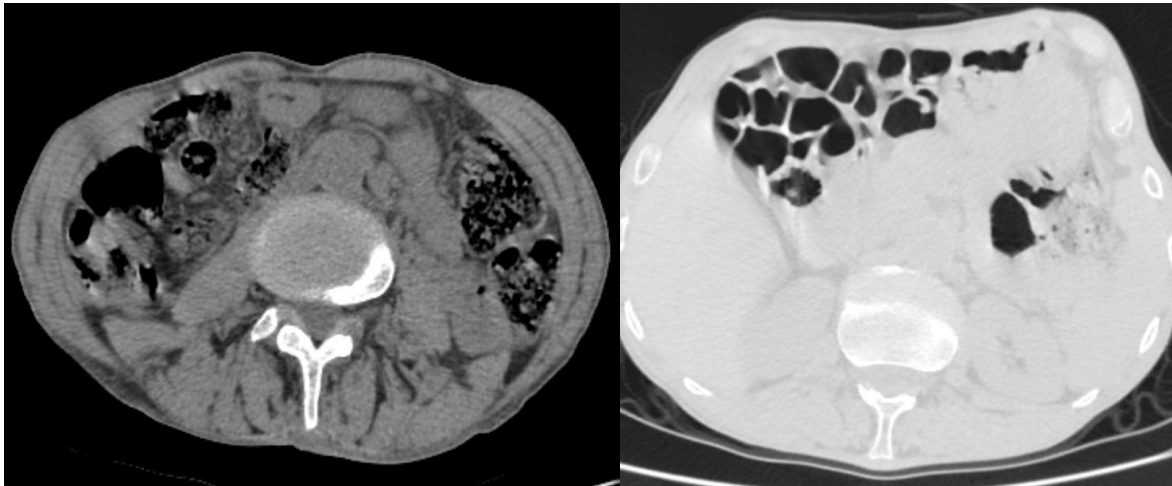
CT scan after 4 months
